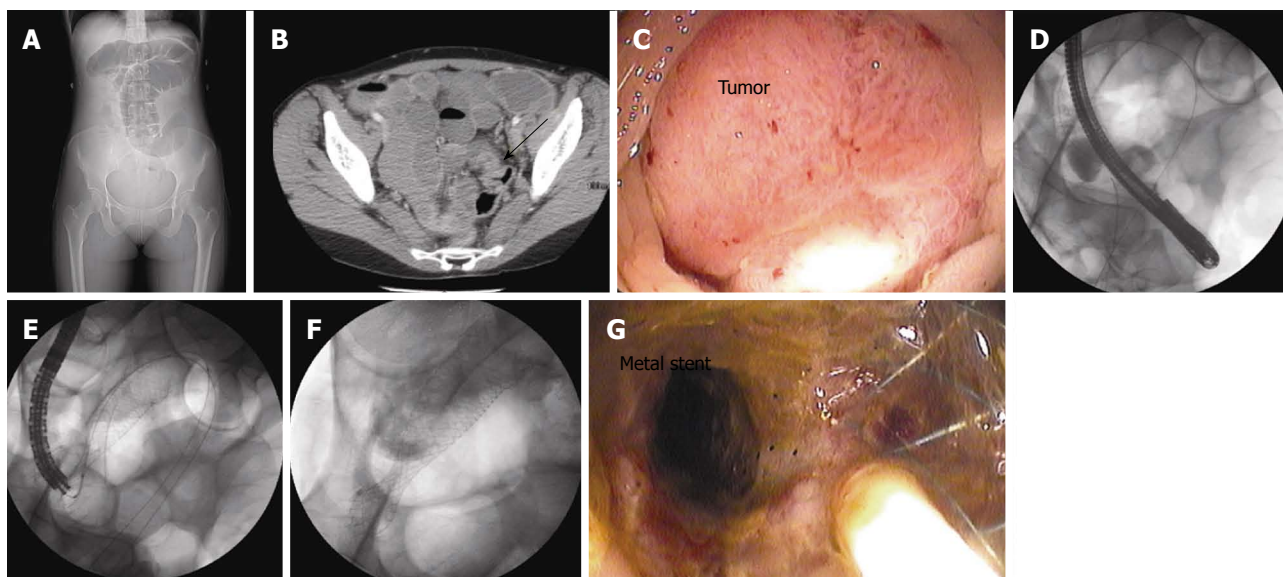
A young patient was diagnosed with an obstructing cancer in the upper rectum. Computed tomography demonstrated findings consistent with peritoneal metastases. She was referred for an endorectal stent to relieve the obstruction. A: Single-view plain radiography demonstrated colonic distension; B: A single-axial section with the arrow demonstrated the tumor; C: Luminal view of the tumor at time of sigmoidoscopy; D: Fluorography during stent placement demonstrated the wire across the tumor; E: Fluoroscopic view demonstrated the endoluminal stent being deployed; F, G: Fluoroscopic and endoscopic views of the stent in place.
